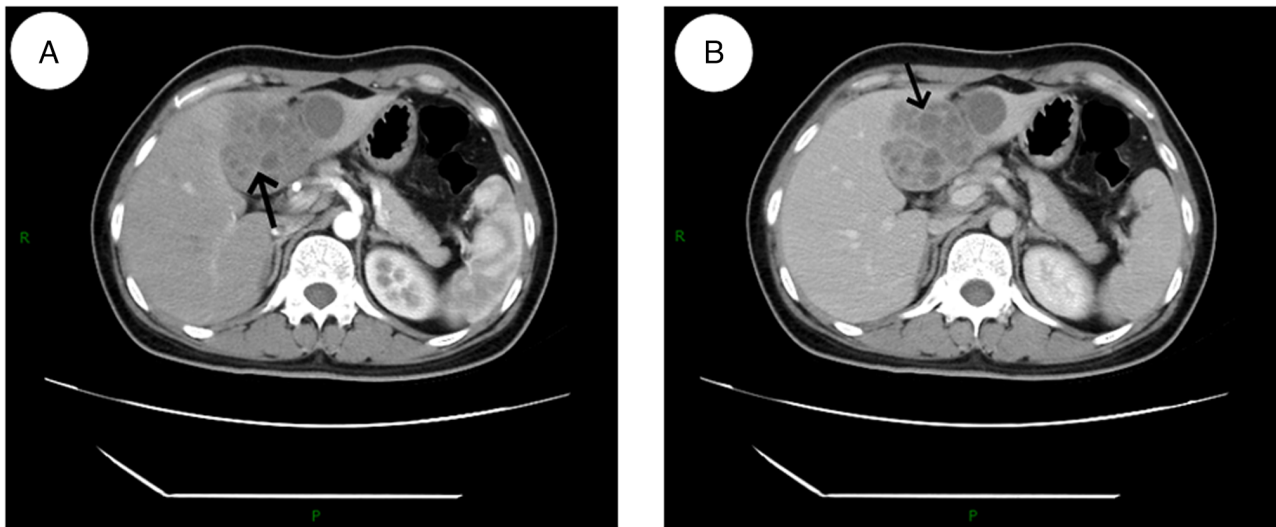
Preoperative abdominal CT examination results. (A) Contract-enhanced CT scan of the liver in the arterial phase after iohexol injection, showing enhancement at the edges and septation (arrow). (B) CT images in the venous phase showing multiple quasi-circular, small, patchy, low-density lesions (arrow). CT, computed tomography; P, CT section was started from the posterior side; R, CT section was started from the right side.
